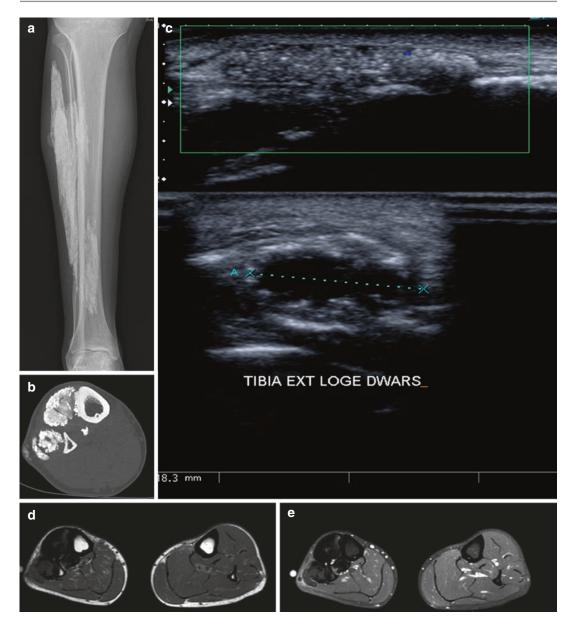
A 52-year-old male with a fusiform mass in the right lower leg and a previous history of motor vehicle accident 34 years previously: (a) plain radiograph, (b) axial CT of the right lower leg, (c) longitudinal (*upper image*) and axial (*lower image*) ultrasound, (d) axial T1-weighted MR image, and (e) axial FS T1-weighted MR image after administration of gadolinium contrast. Plain radiograph (a) reveals peripherally plaque-like calcifications anterolaterally in the right lower leg. On CT, the lesion is located within the anterior and peroneal compartment. The calcifications are denser in the periphery
